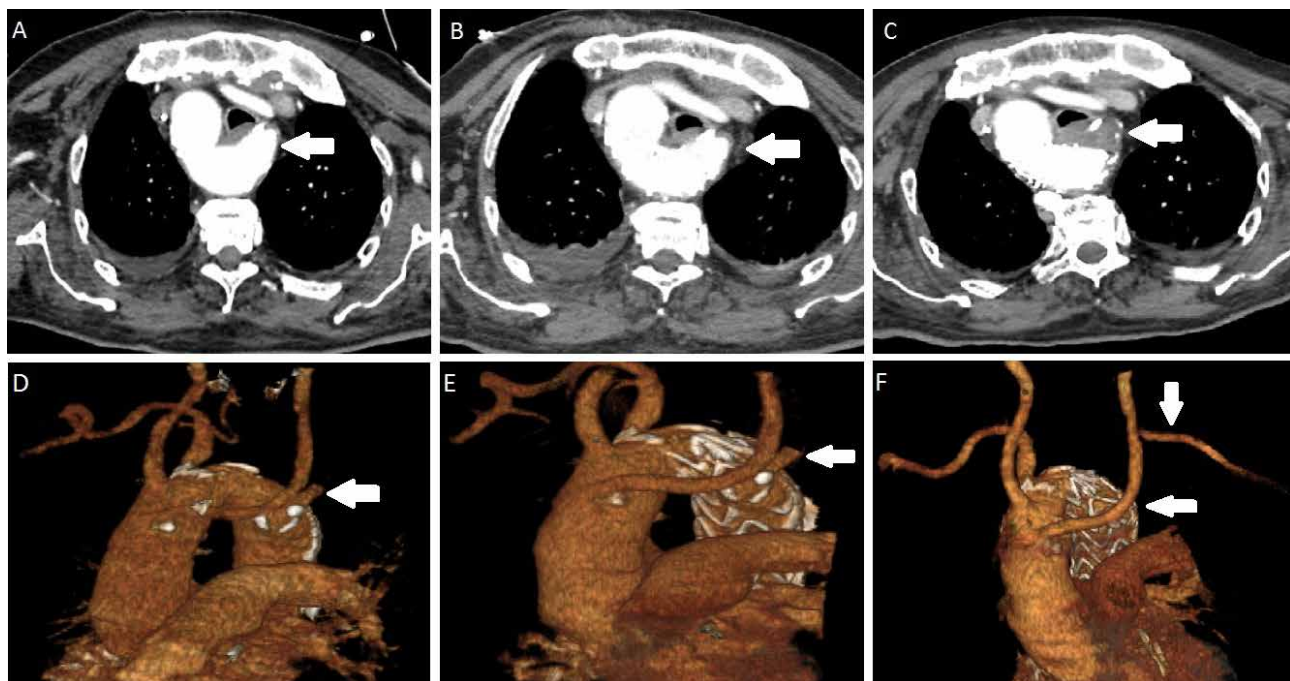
Preoperative (A, D), after TEVAR (B, E), after left subclavian artery to carotid artery transposition computed tomography scans (C, F)
